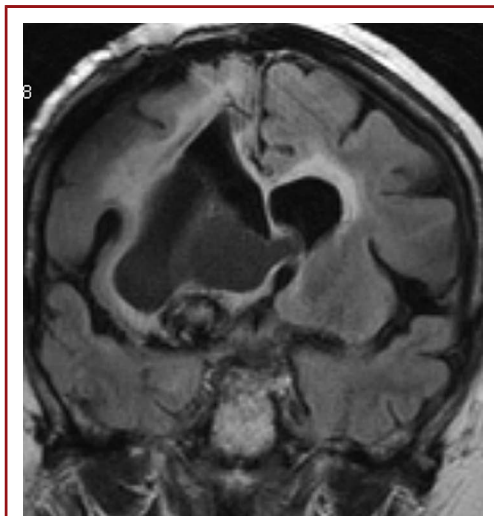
Magnetic resonance image showing the expansive process above the previously coiled aneurysm 5 years after the first craniotomy, a few days before the second craniotomy (coronal section).
